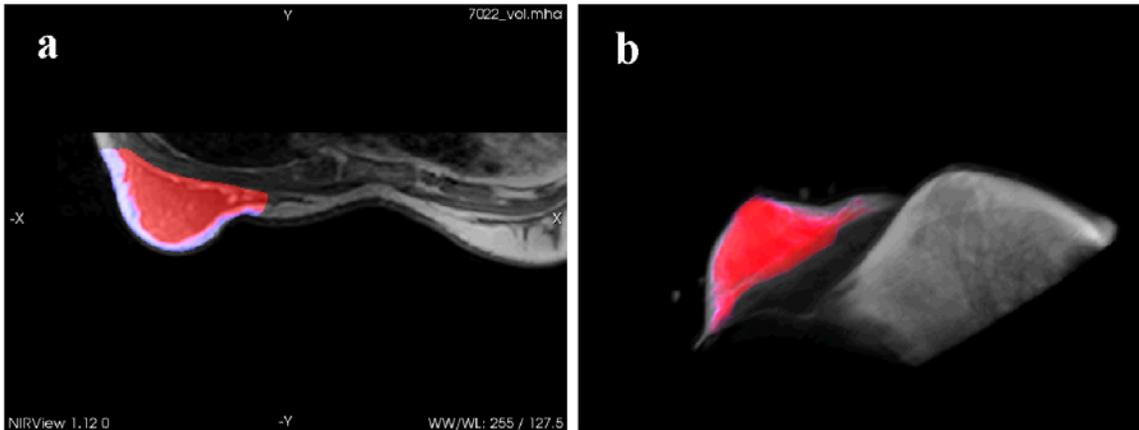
Visualization of the reconstructed values for total hemoglobin in the breast, rendered as an overlay of the original MR images of the breast with custom color/opacity settings. (a) Shows the optical solution overlay in 2D on a single MR slice; (b) Shows the optical solution overlay in 3D on the MR volume.
